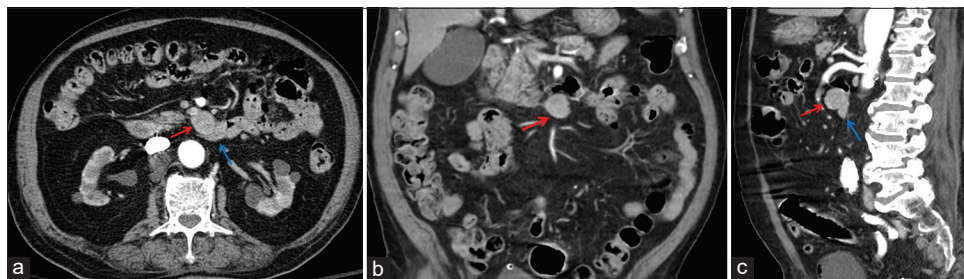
An 87-year-old male who presented with bloody bowel movements diagnosed with superior mesenteric vein (SMV) aneurysm. (a) Contrast-enhanced computed tomography (CT) scan of the abdomen axial view showing a 2.2 cm venous aneurysm (red arrow) of the SMV branch with the aneurysm located anterior to the 4th portion of the duodenum (blue arrow). (b) Contrast-enhanced CT scan of the abdomen coronal view showing a 2.2 cm venous aneurysm (red arrow) of the SMV branch with the aneurysm located anterior to the 4th portion of the duodenum (blue arrow). (c) Contrast-enhanced CT scan of the abdomen sagittal view showing a 2.2 cm venous aneurysm (red arrow) of the SMV branch with the aneurysm located anterior to the 4th portion of the duodenum (blue arrow).
